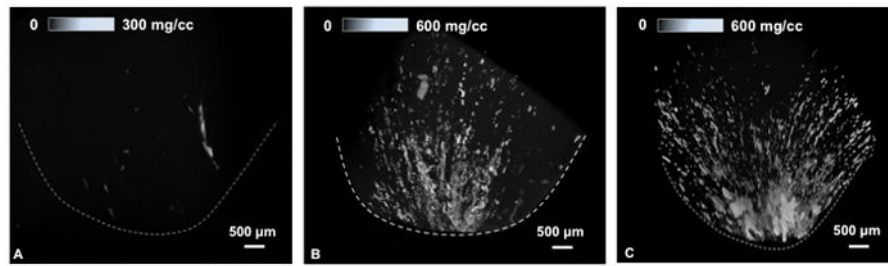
Micro-computed tomography of human medullo-papillary complex. From left to right, a comparison of increasing mineralization is detectable in 3 subjects. Streaks and aggregates of mineralized regions in Zones 1 and 2 are predominantly intratubular in location. With greater proximal mineralization, distal interstitial mineralization becomes apparent. Upper scale bars represent gradients in mineral densities within the medullo-papillary complex.
